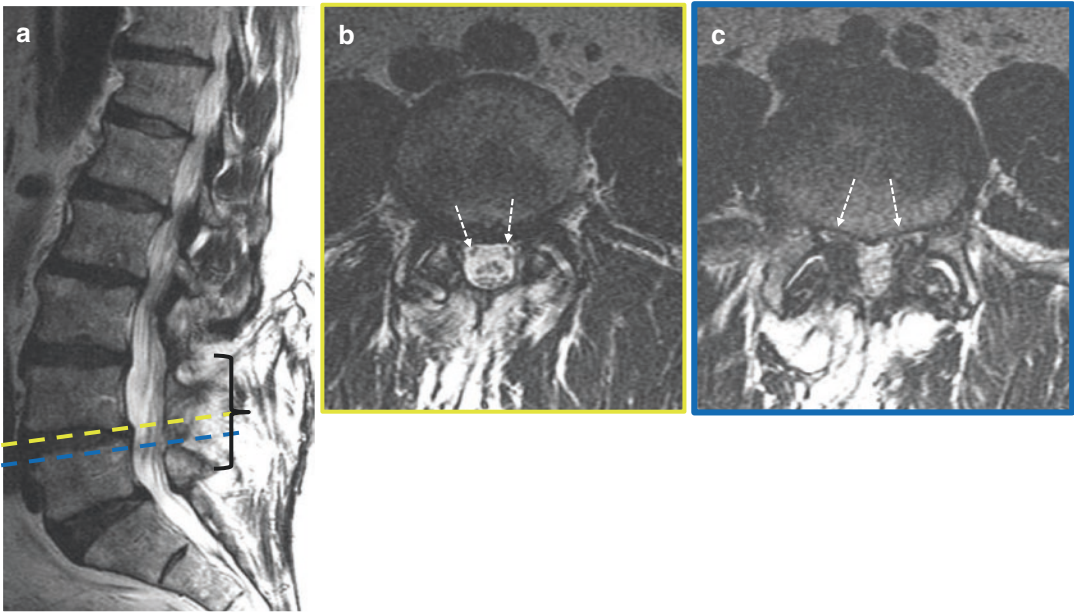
A 69-year-old man status post-L4–5 midline laminectomy (bracket, a). Axial T2-weighted MR image (b) at the L4–5 disc space (dashed yellow line, sagittal T2-weighted MR image, a) demonstrates severe compression of the L5 nerve roots (arrows) within the lateral recess. Axial
